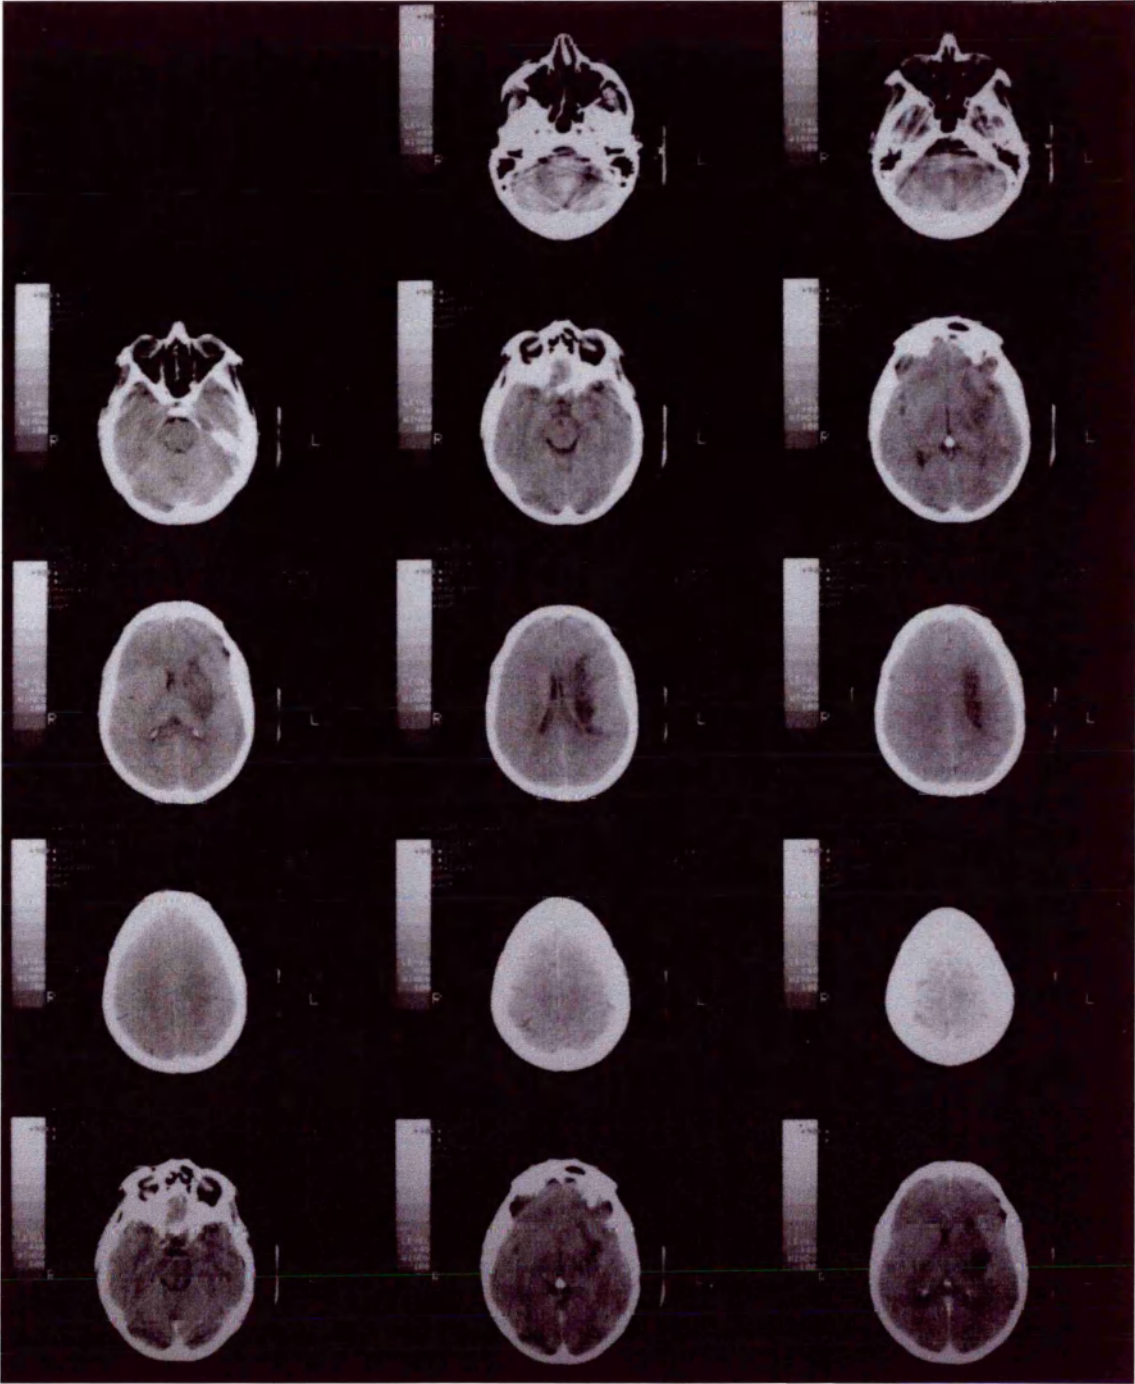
CT scan for IE.
